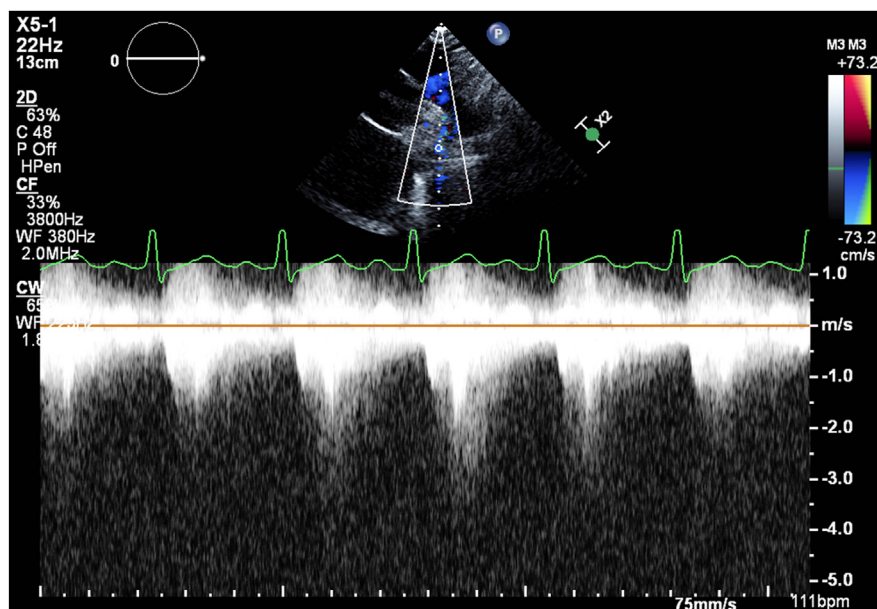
Two-dimensional TTE, continuous-wave Doppler across descending aorta, demonstrates abnormal forward flow in diastole and a peak Doppler velocity of 2.5 m/sec.
